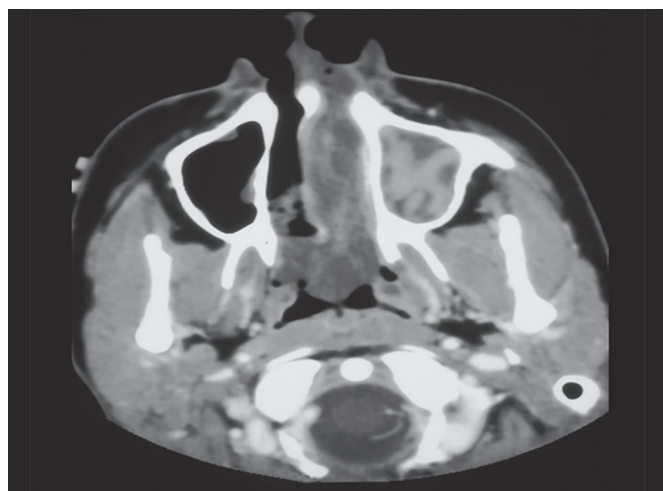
Sinus CT of a patient with allergic fungal rhinosinusitis shows hyperdensities within the sinuses.
